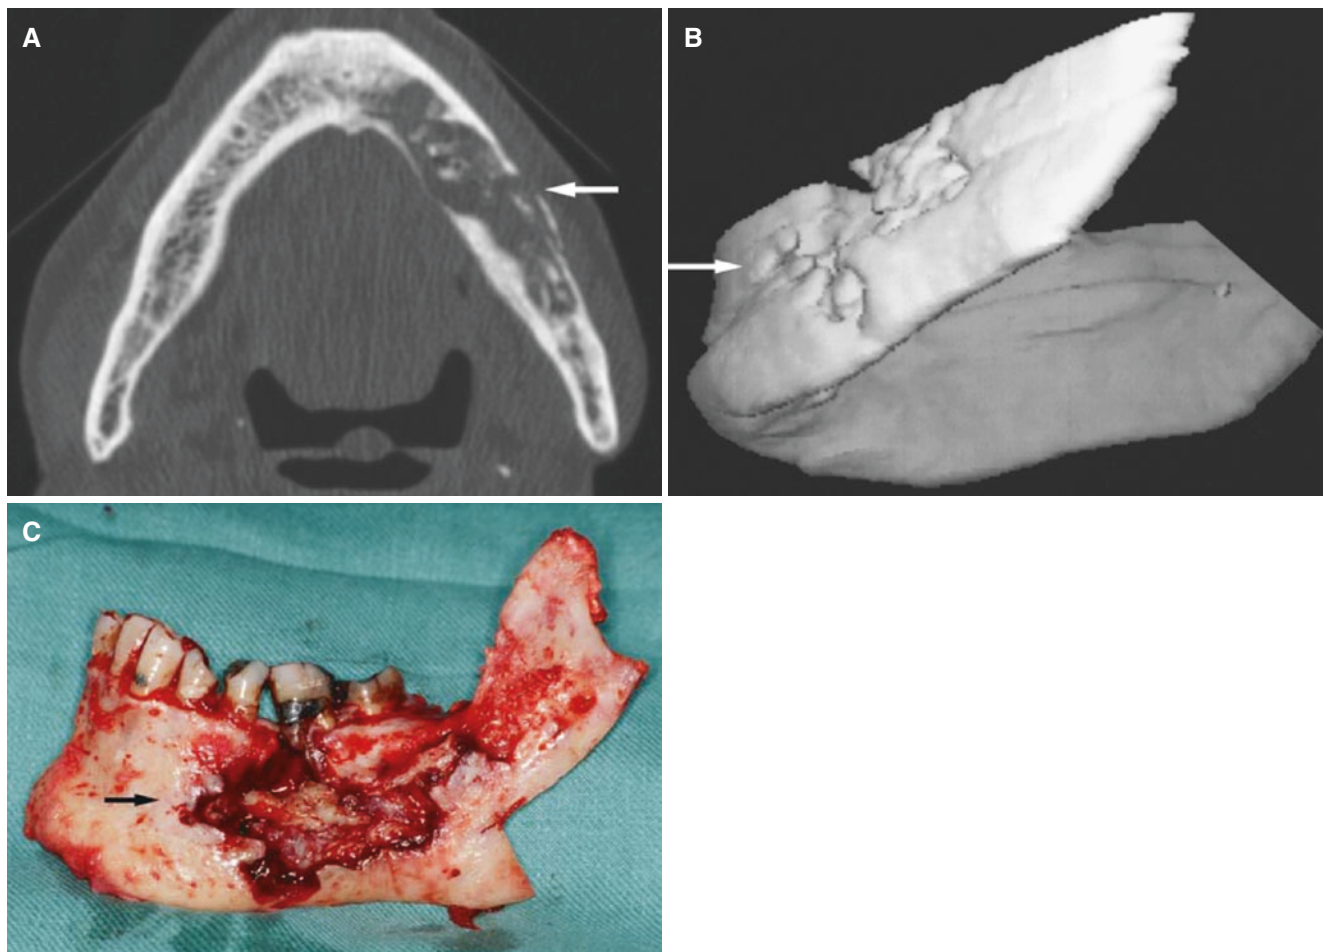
Osteoradionecrosis, mandible; 79-year-old male with extensive bone destruction and severe symptoms. (A) Axial CT image shows severe destruction of left mandibular body (*arrow*). (B) 3D CT image
